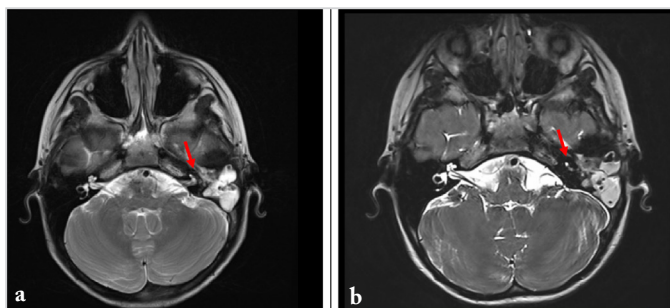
a, b) T2-weighted magnetic resonance images axial cuts showing the external auditory canal, the middle ear cavity, the aditus and mastoid air cells are filled with contents appearing T2 hyperintense with patchy restriction on diffusion, with loss of T2 hyperintensity in cochlear turns and semicircular canals on left side (red arrow)
